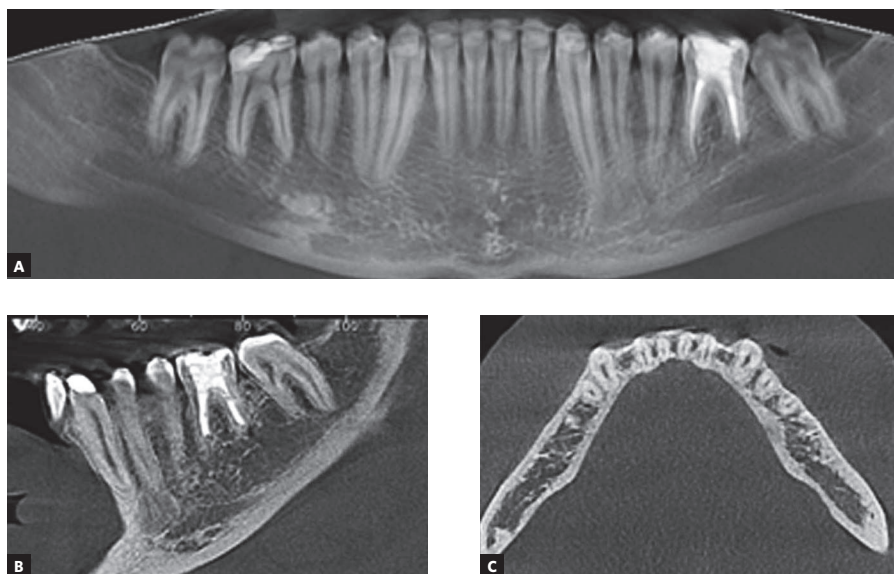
Last follow-up CBCT (March/2019): (A) coronal-panoramic image; (B) sagittal image; (C) axial image.
